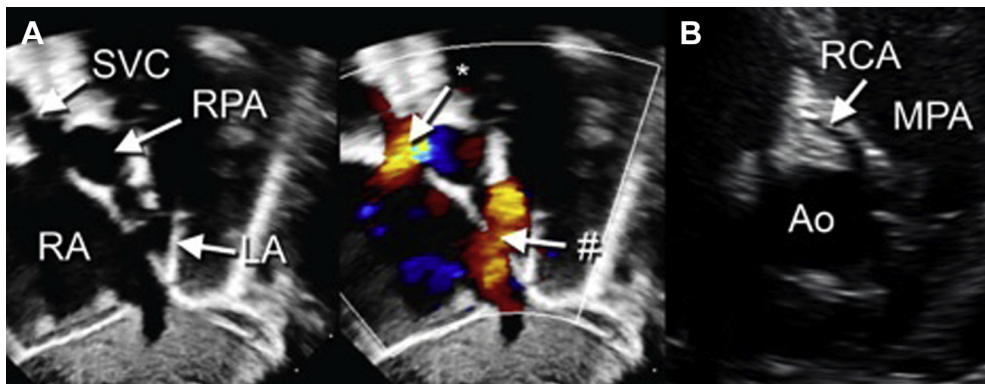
Preoperative transthoracic echocardiography at 8 months of age. (A) Subcostal sagittal view demonstrates inferior sinus venosus defect (*pound sign*) and partial anomalous pulmonary venous return of the right upper pulmonary veins to the superior vena cava (SVC)–right atrium (RA) junction (*asterisk*). (B) Deceptive two-dimensional imaging from the parasternal short-axis view suggested normal origin of the right coronary artery (RCA) into the aorta (Ao). LA, Left atrium; MPA, main pulmonary artery; RPA, right pulmonary artery.
